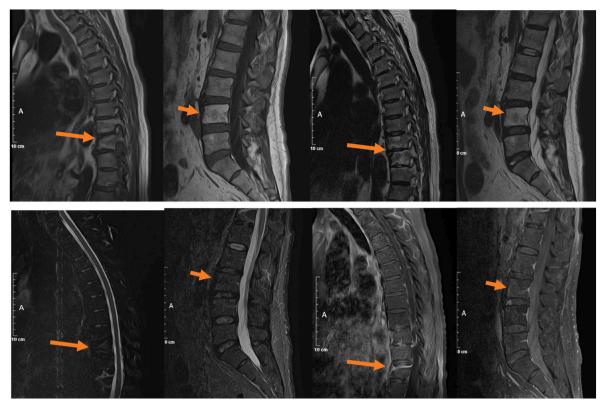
Thoracic and lumbar Nuclear Magnetic Resonance image in T1, T2, Short Tau Inversion Recovery sequences and T1 sequence contrasted with Gadolinium, osteolytic lesions in T9-L5 vertebral bodies near full remission, but with persistent kyphosis.
